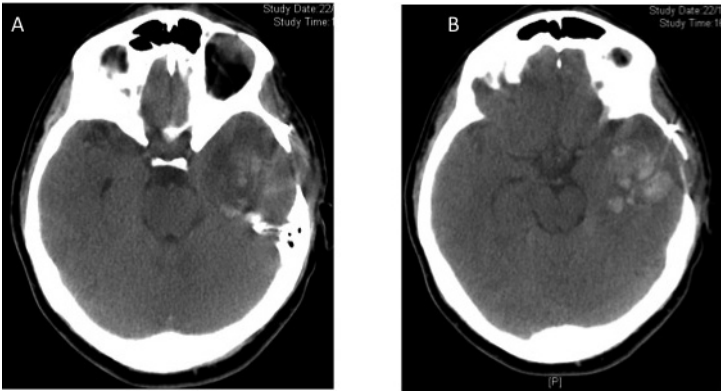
A, B) 2-month CT scan showing the new bleeding in the left temporal lobe.
